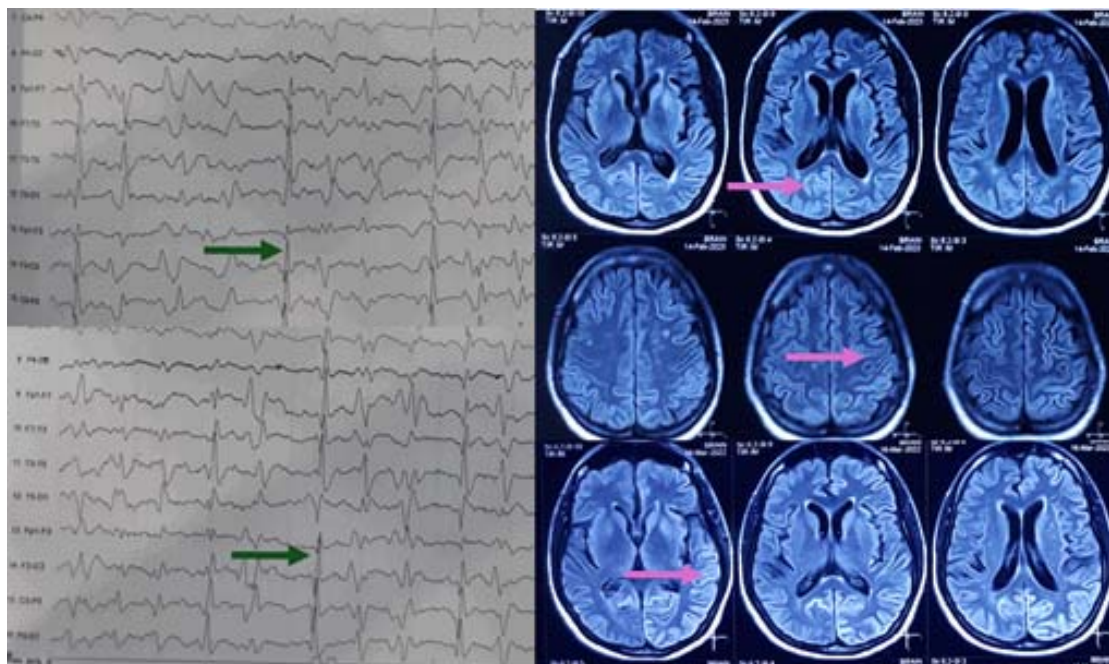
MRI showing evidence of cortical ribboning (Pink arrow) and Periodic sharp waves on the EEG (Green arrow).
